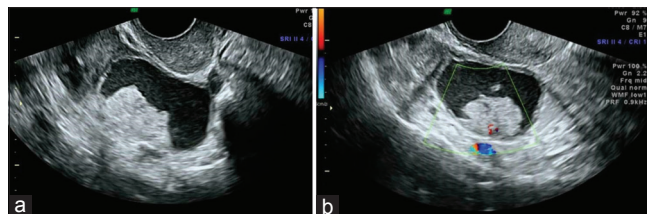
Gynecologic Imaging Reporting and Data System V. (a) A cyst with thick wall and a large irregular model inside it. (b) In Doppler study, clear vascularity was seen
